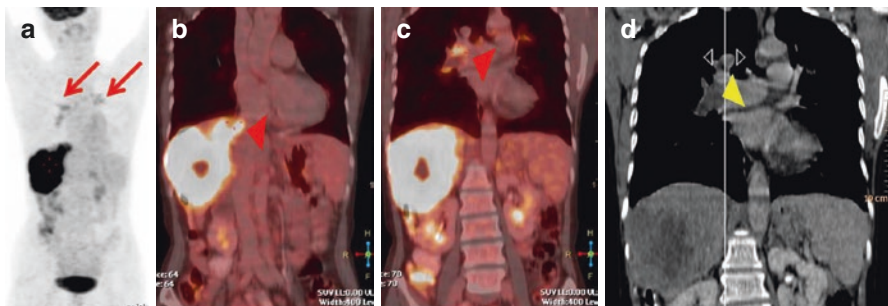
Case of HCC involving the right lobe of the liver with portal thrombosis, patient was planned for trans arterial radioembolization and hence referred for a staging FDG PET/CT study. Intense FDG uptake was seen in the tumor involving a large part of the right lobe with uptake also seen in the portal vein thrombosis as seen on the MIP (a) and the coronal fused images (arrow head in b). Increased uptake is seen in the thoracic region bilaterally on the MIP image (arrows in a) which corresponds to filling defect seen in the pulmonary vein in the coronal-fused images (arrow head in c). The CECT of the thoracic region in the coronal image confirms the presence of bilateral pulmonary thrombosis (arrow head in d)
